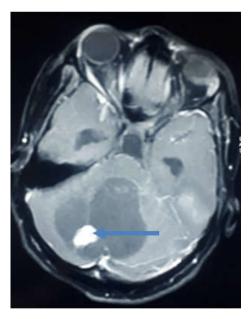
Axial post contrast T1 MRI image showing intensely enhancing mural nodule (arrow)
